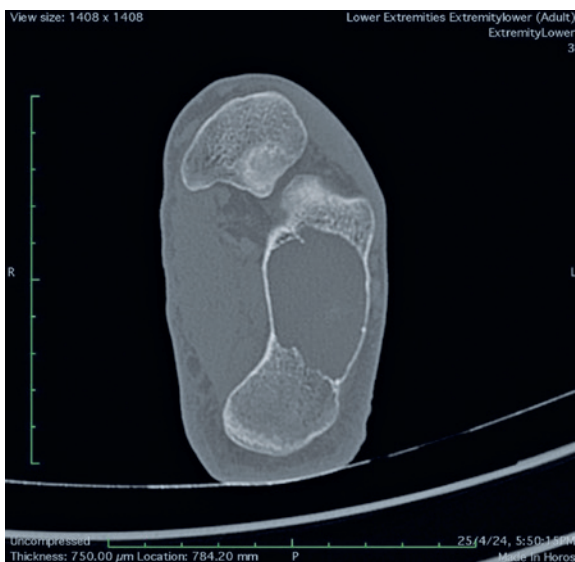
A computed tomography scan revealing a large fluid-filled cystic lesion (46x29x22mm) with a sclerotic but thin cortical margin.
